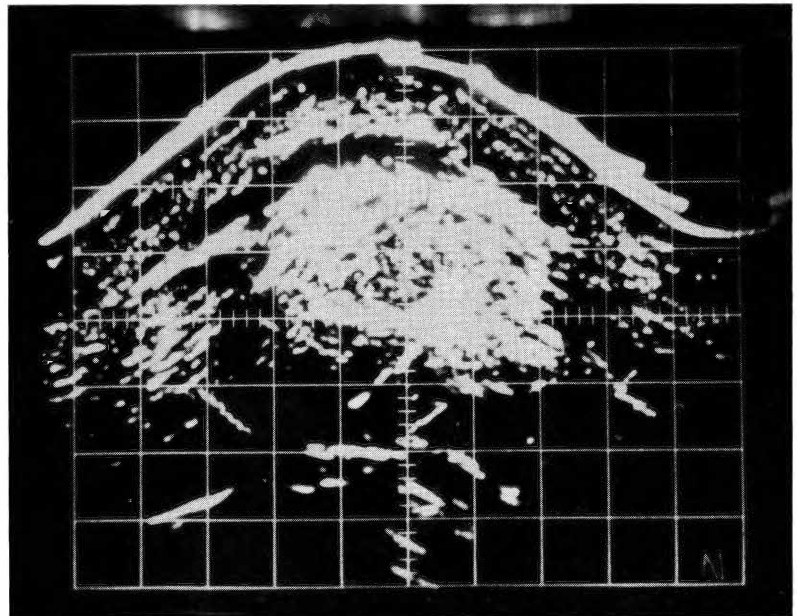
Sonogram of anterior abdomen in a patient with metastatic carcinoma throughout the anterior abdomen confirmed by autopsy. The dense echo pattern obtained can be contrasted with the echo pattern of the previous Figure. Presented at Miami meeting, American Institute for Ultrasound in Medicine, Miami, 1967.
